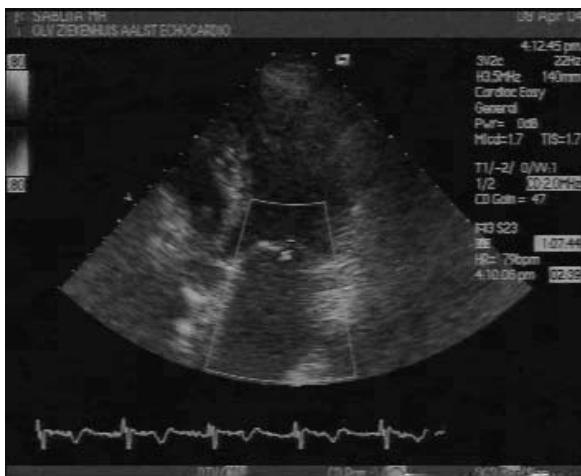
Mitral regurgitation at rest before cardiac resynchronisation therapy, parasternal long axis view
